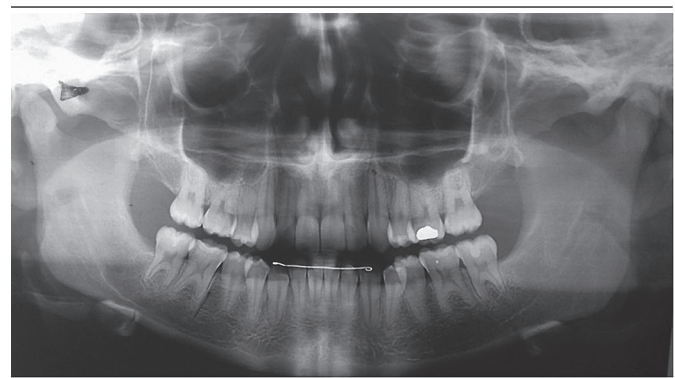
Panoramic radiograph showing bone formation in the area approached
